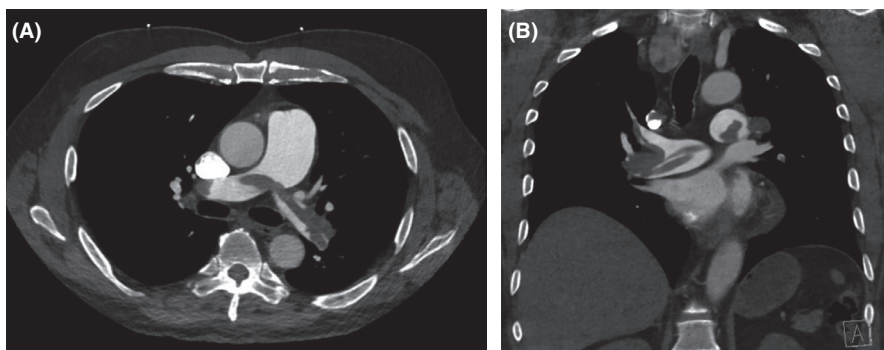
a. b. Axial (1a) and coronal (1b) CT images show saddle pulmonary embolus extending from the main pulmonary artery (PA) into both the right and left main pulmonary artery
